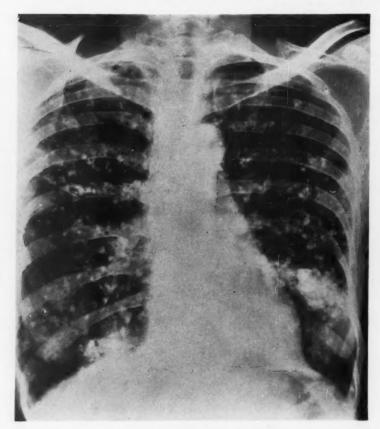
Chest x-ray, March 20, 1956.
